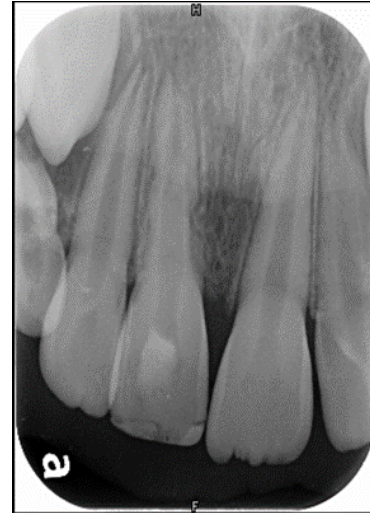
Intraoral periapical radiograph at 6 months post pulpectomy showing evidence of a calcific barrier formation at the apex.
